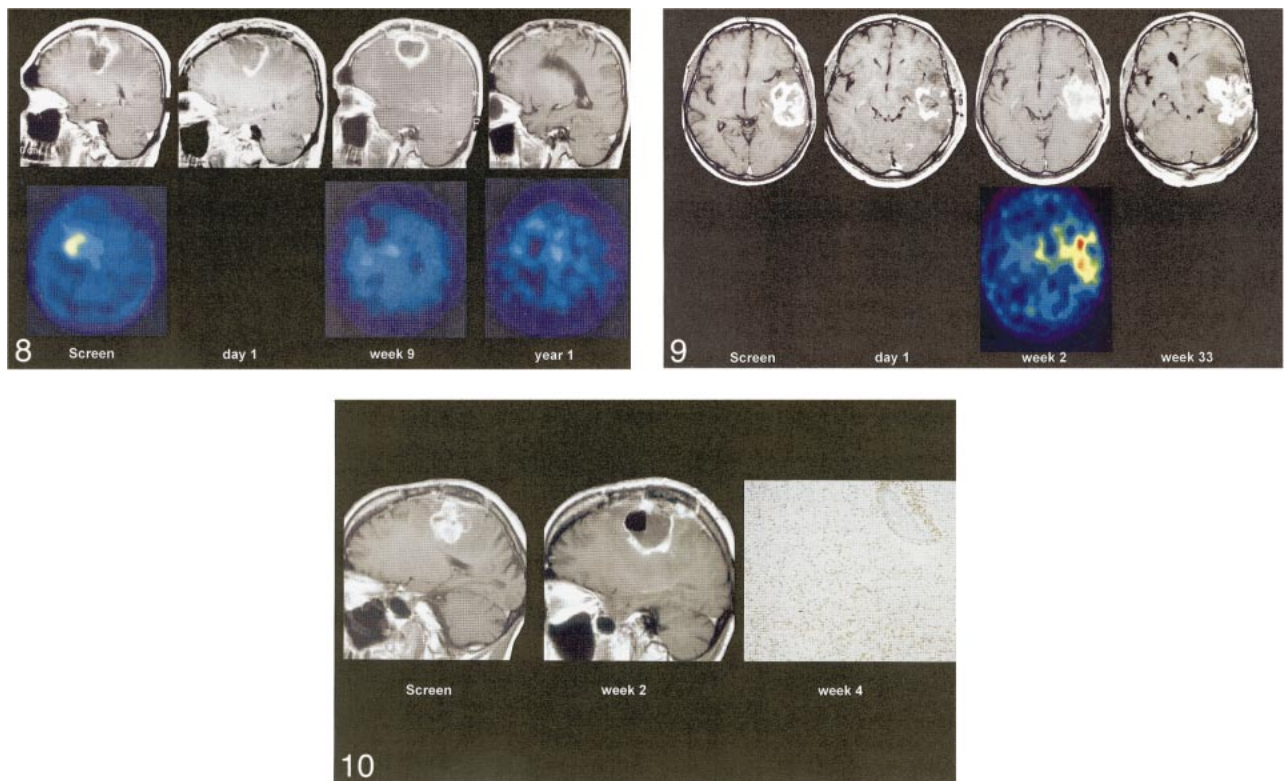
Flare enhancement at IMT-SPECT. Scans obtained preoperatively and on day 1, week 9, and year 1 postoperatively show enhancement on MR images (*upper line*) and amino acid uptake on IMT-SPECT scans (*lower line*). Although preoperative tumor enhancement on MR images corresponds with an increased amino acid uptake on SPECT scans, the postoperative flare on MR images shows no raised amino acid uptake on SPECT scans (enhanced T1-weighted sagittal MR images and IMT-SPECT scans, patient 1).
